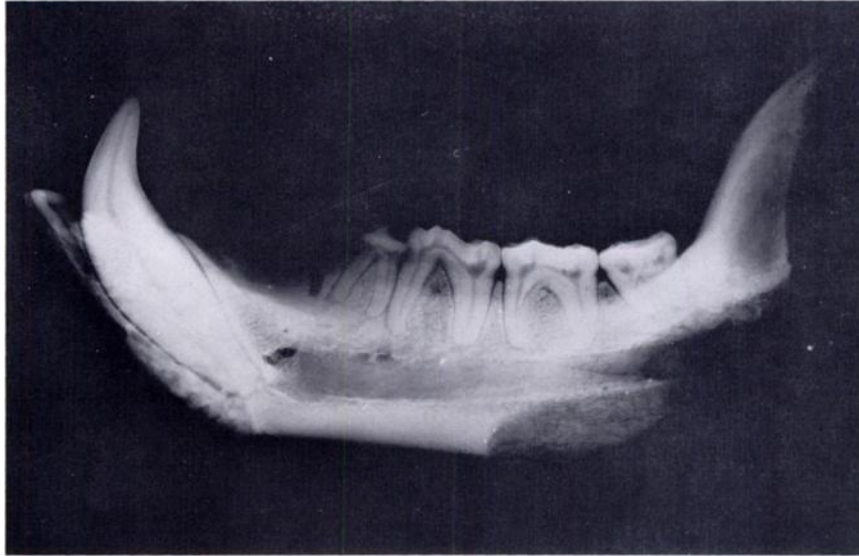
Radiograph (lateral view) of injured left mandible of *Ursus americanus*. Remains of the bullet show up as white flecks.
